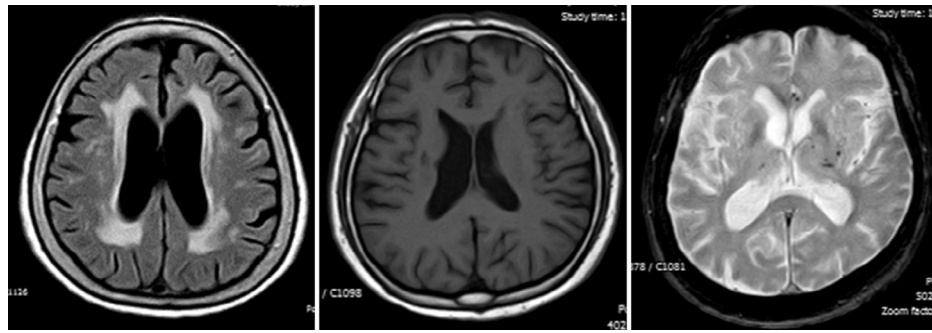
Silent markers of cerebral small vessel disease on MRI. From left to right: severe white matter hyperintensities of presumed vascular origin (fluid-attenuated inversion recovery – TR 9000, TE 120, TI 2500), lacunar infarct in right subcortical white matter (T1-weighted – TR 594, TE 15), and deep microbleeds (gradient-echo – TR 686, TE 23). Images correspond to three different people aged ≥ 60 years.
